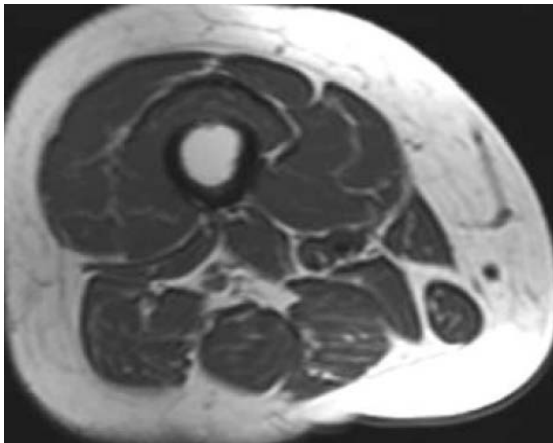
Axial T1-weighted image of the thigh demonstrating the normal appearance of skeletal muscle [31]
